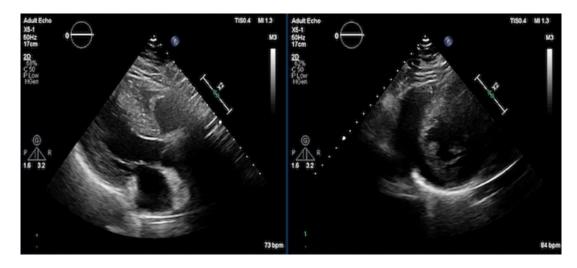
Transthoracic echocardiography showed concentric left ventricular hypertrophy (maximal wall thickness 20 mm) from parasternal long axis, short axis.
